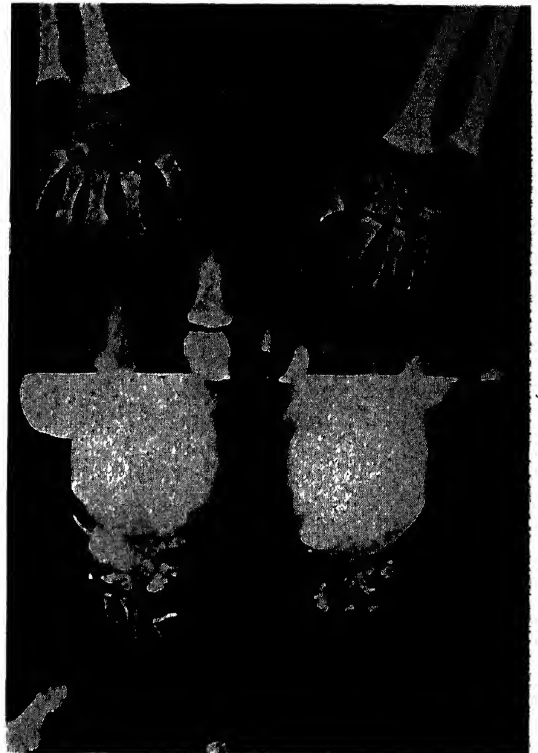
Living twin at 10 months. Note calcific deposits in wrists and ankles. (G. Raap: Am. J. Roentgenol.)
